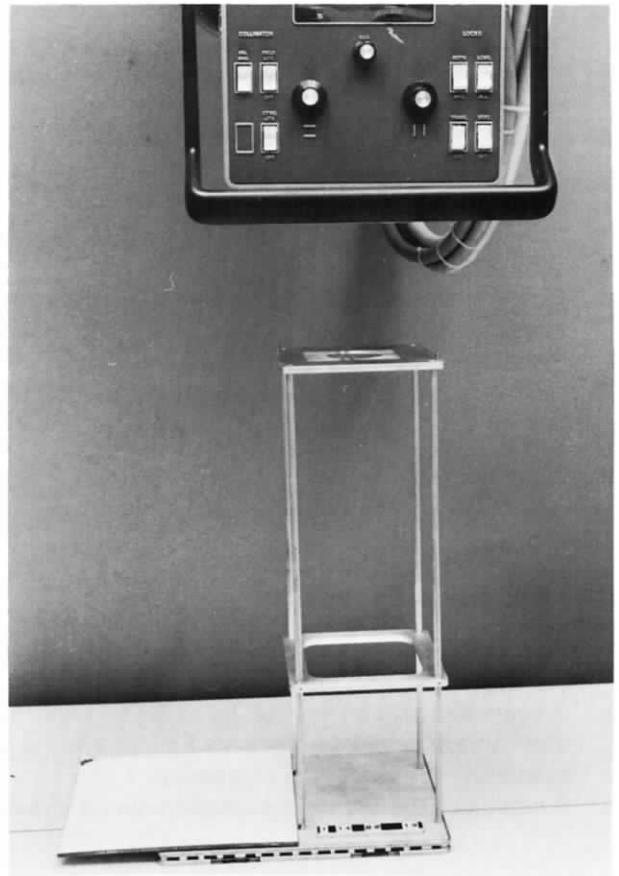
X-ray tube focal spot size star measurement test setup. The star test target (see Figure 7.11) is placed on top of the stand and an image is produced using an extremity cassette system. Images made with both the large and small focal spot can be placed on the same sheet of film.
